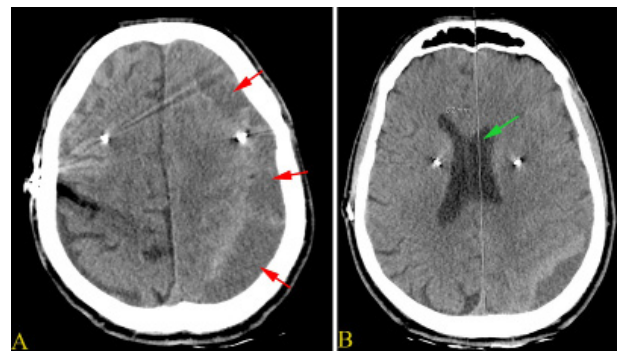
(A) Preoperative CT showing the hypodense chronic subdural hematoma with hyperdense areas, marked by red arrows. (B) Preoperative CT showing 8.2 mm midline shift, marked by the green arrow.
